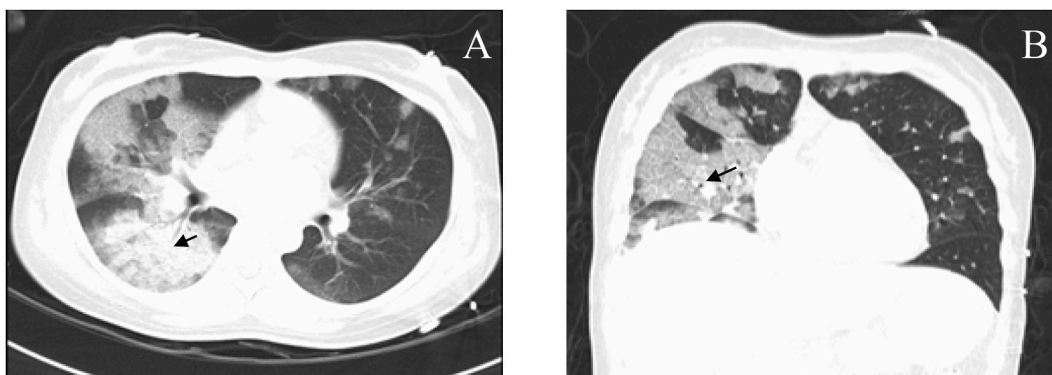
Chest CT reexamination within 48 hours showed DAH progressed to more extensive infiltrates (A and B).
